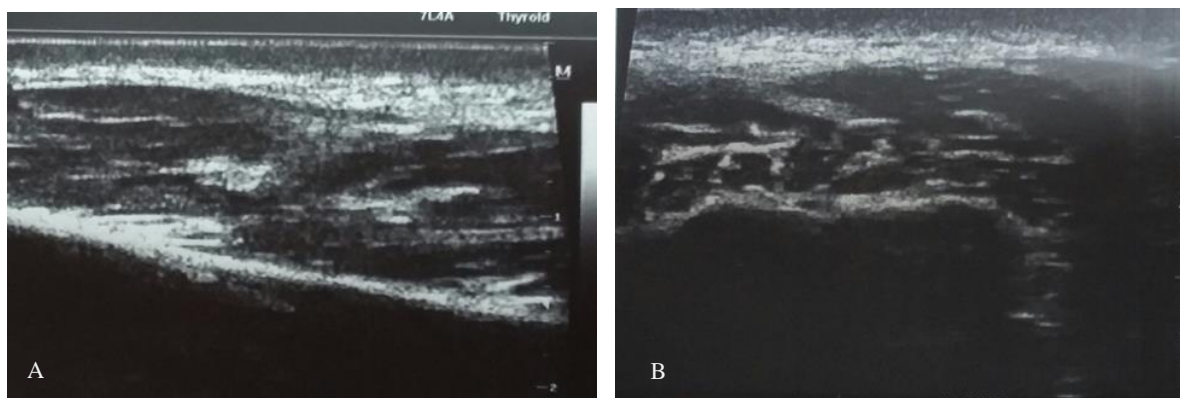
Ultrasonographic measurements of right (A) and left (B) masseter muscle in OSMF patient shows normal echo parenchymal
